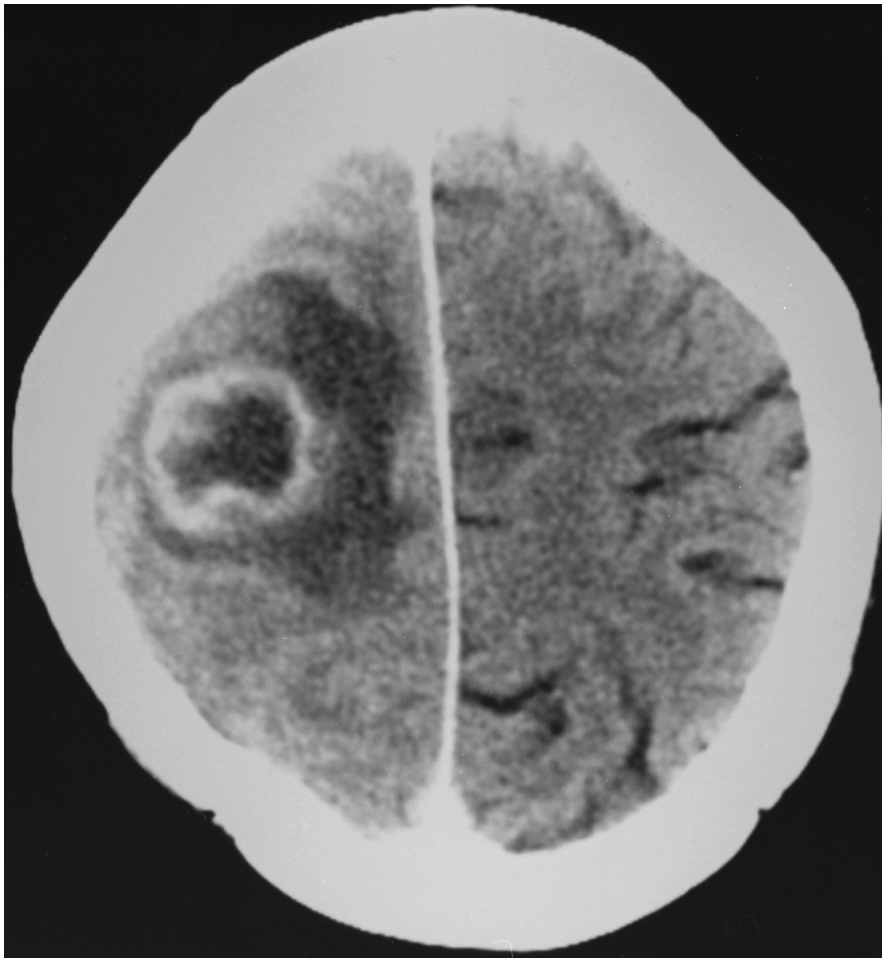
Enhanced axial computed tomography scan showing right parietal subcortical ring-enhancing glioblastoma multiforme with significant surrounding edema and mass effect.
